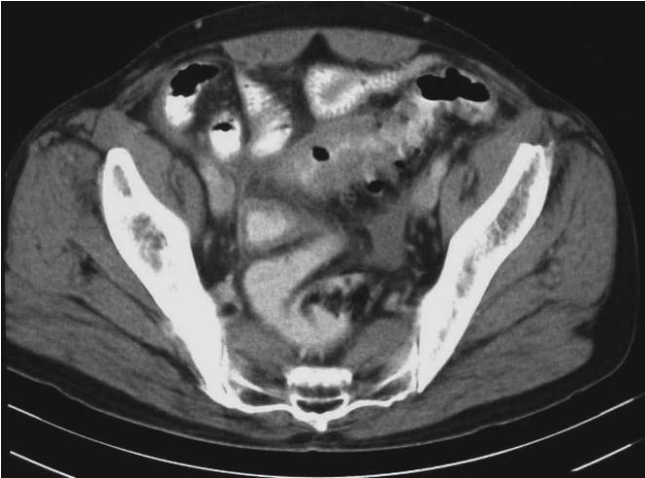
Abdominal CT: acute sigmoid diverticulitis. Note the thickened loop of sigmoid with almost absent lumen and the tissue stranding around it – denoting inflammation
